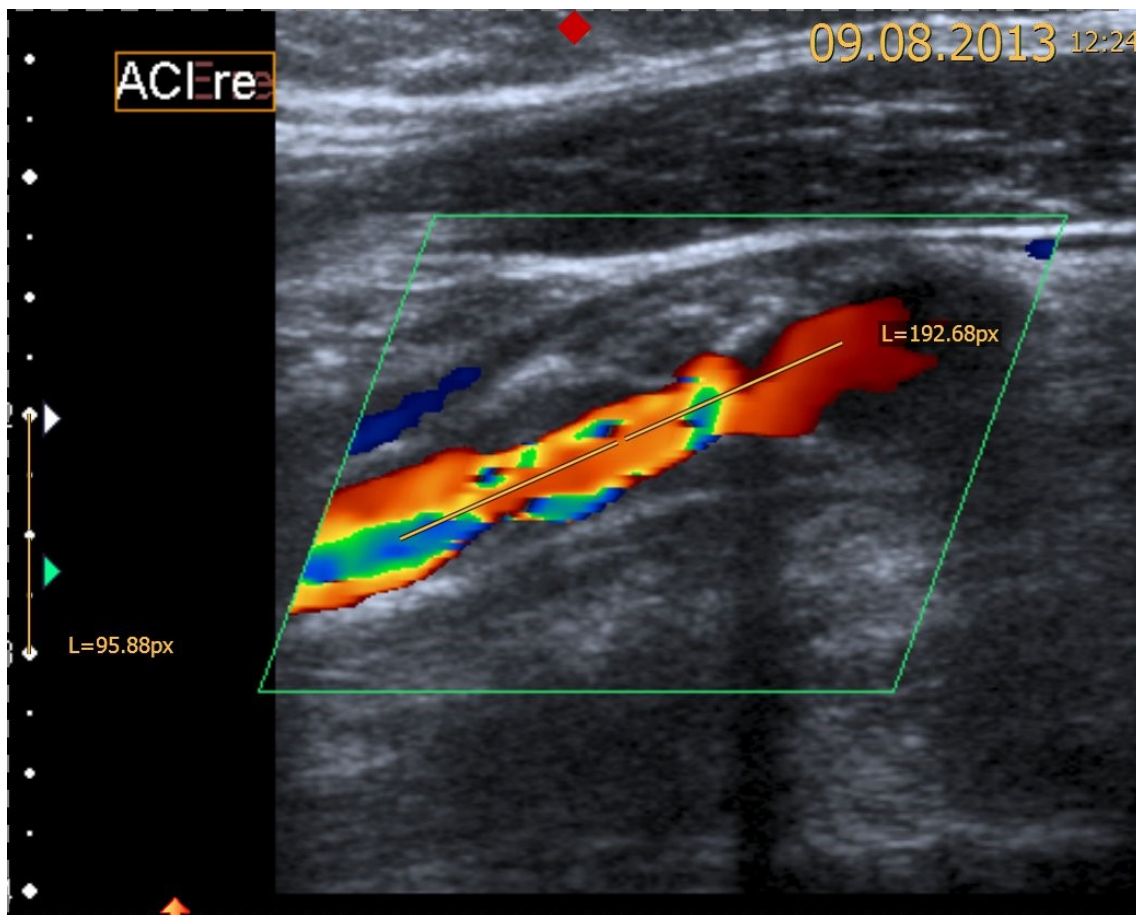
Ultrasound examination (patient 66) showing a stenosis of 20-40%, with a length of 20 mm on the right side
